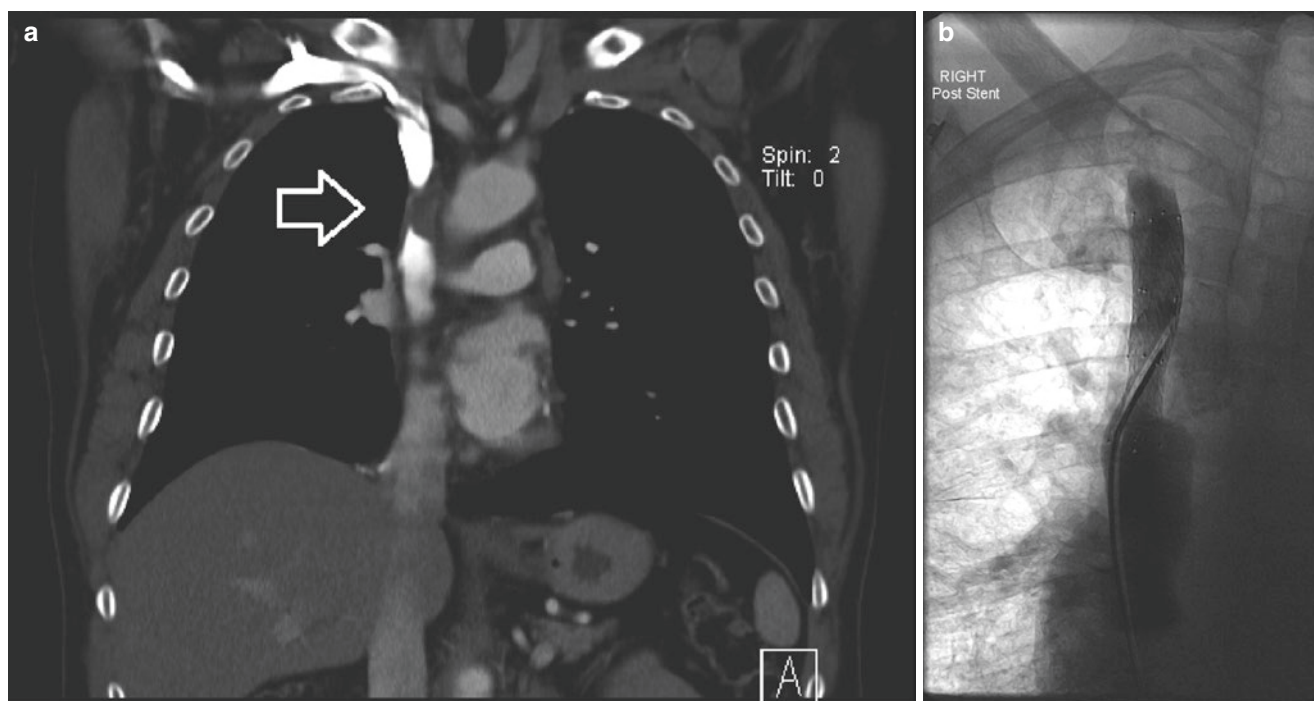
(a) CT coronal view of superior vena cava syndrome. *White open arrow* indicates area of narrowing on contrasted study. (b) Deployment of a stent across the superior vena cava
